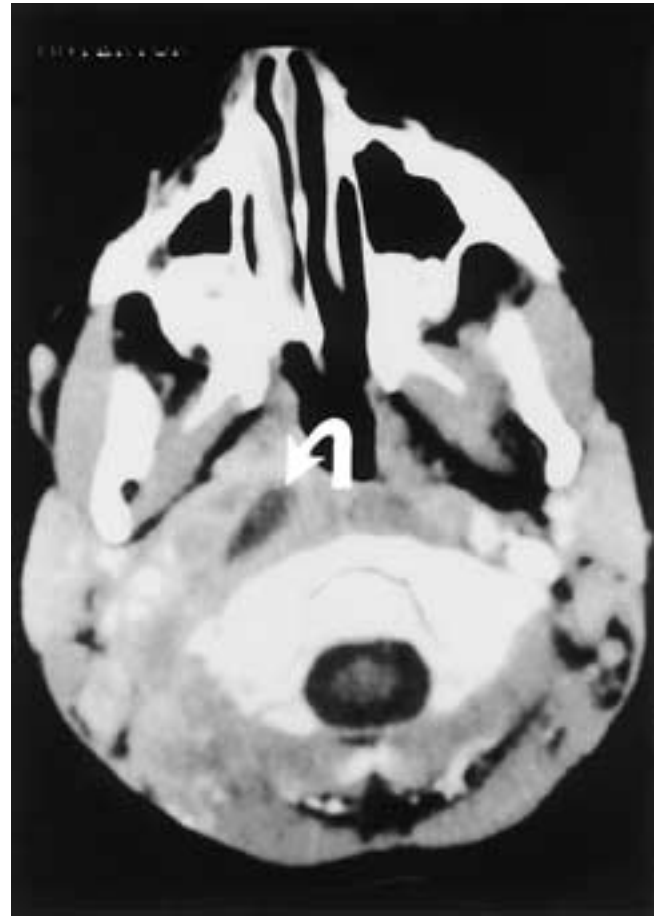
Axial contrast-enhanced CT scan demonstrates an oval-shaped, low-attenuation lesion (*arrow*) in the expected location of a lateral retropharyngeal lymph node. This is the typical finding of a suppurative retropharyngeal adenitis.
